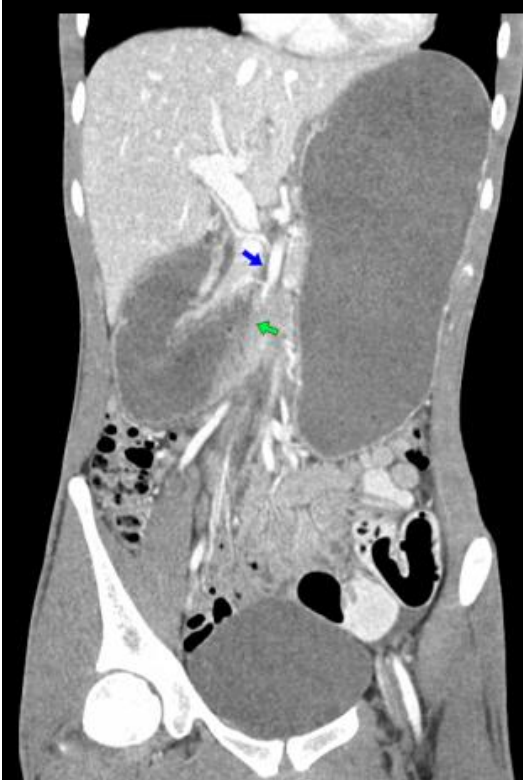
Coronal CT images showing grossly dilated gastric cavity and proximal duodenum. The transition point (green arrow) is at the origin of the SMA (blue arrow) from the aorta.
